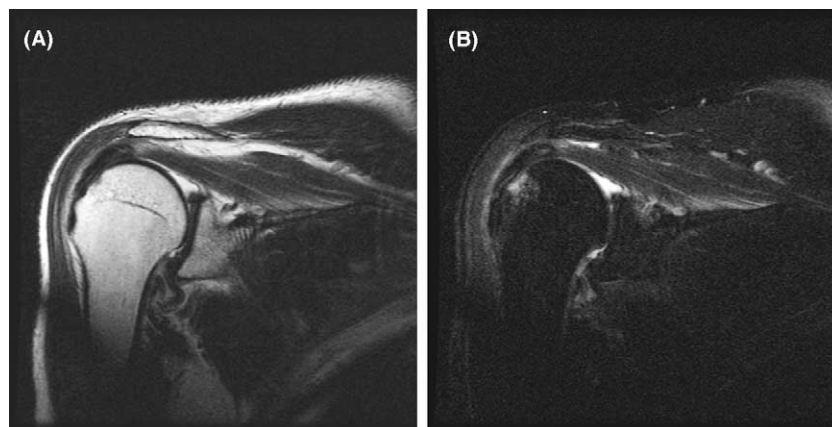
(A) T2-weighted coronal MRI view reveals a partial tear of the supraspinatus tendon. (B) T2-STIR coronal MRI view reveals high intensity in the greater tubercle, indicating bone contusion.
